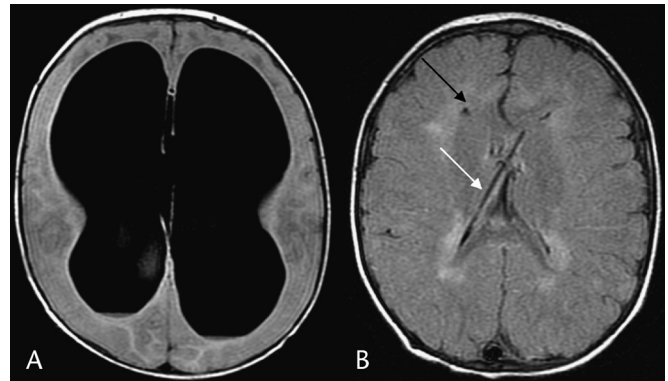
Communicating HC post-VP shunt in a 4-year-old boy. A, Axial FLAIR image at presentation in early infancy demonstrates marked ventriculomegaly with thinning of the cortical mantle. B, Follow-up axial FLAIR image shows a right parietal ventricular catheter in place (white arrow), small ventricles, and increased mantle thickness. The periventricular white matter hyperintensity (black arrow) likely represents undermyelination vs some leukomalacia or gliosis.
